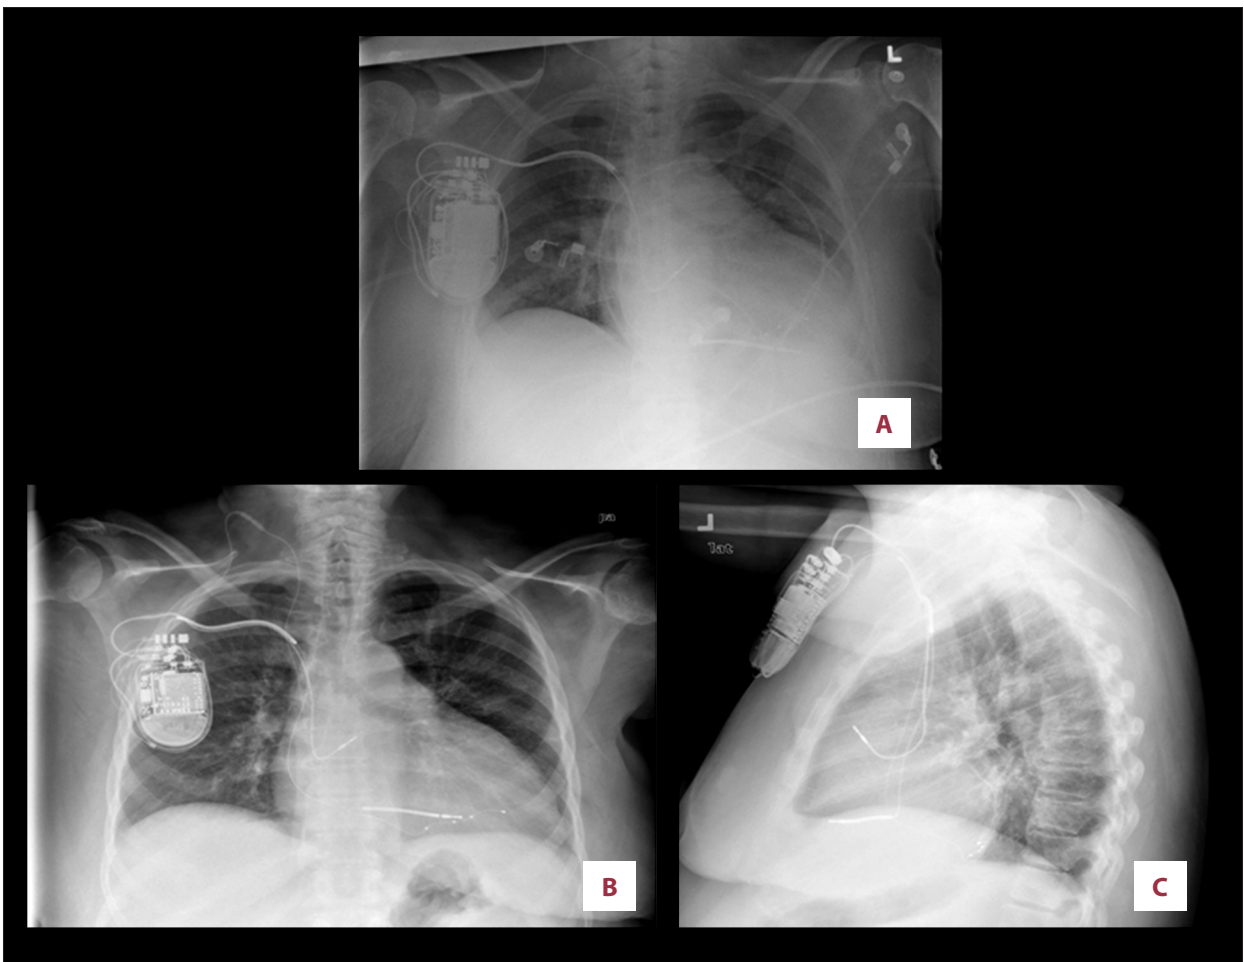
Case 2: (A) Dual chamber ICD before the upgrade; (B, C) Chest x-ray posteroanterior (PA) and lateral view; biventricular ICD in place with the left ventricular lead inserted via right internal jugular vein.
